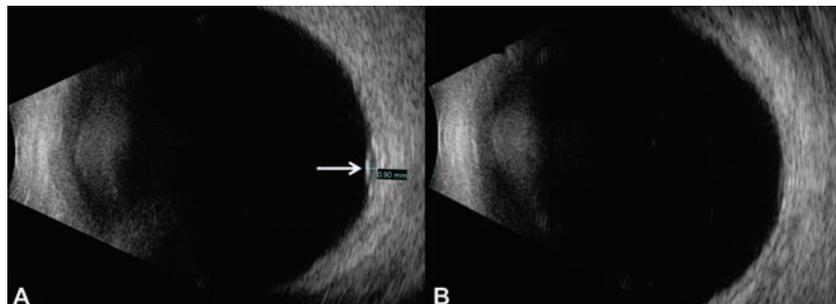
Ultrasonography of the left eye depicting an echolucent, dome-shaped lesion (arrow) with no extrascleral extension. The lesion inflated to 0.90 mm thickness in superonasal gaze (A) and deflated in primary gaze or with digital pressure on the globe (B).
